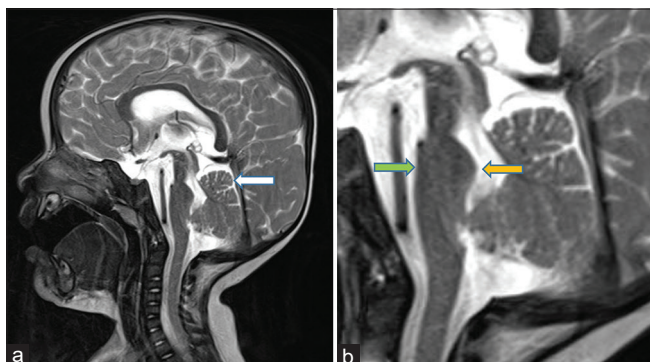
(a and b) MRI brain T2W sagittal images highlighting flattening of the ventral pons (green arrow) and thinning of the isthmus with dysmorphism of the dorsal upper pons (cap like) bulging (orange arrows) and protruding in the fourth ventricle. Mild cerebellar vermal hypoplasia and corpus callosum hypoplasia are seen. MRI = magnetic resonance imaging, T2W = T2 weighted
